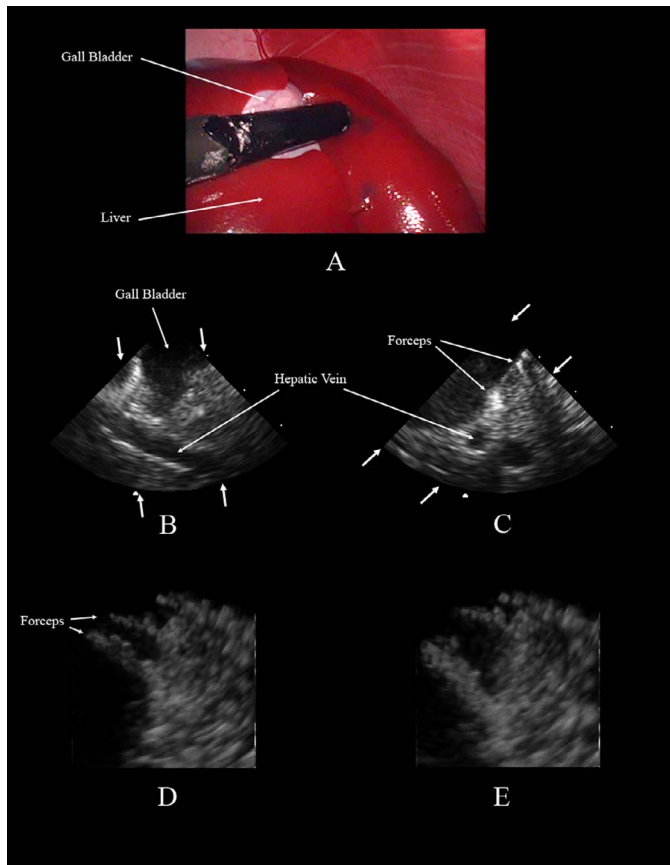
Simultaneous optical laparoscopic view (A) and 3-D laparoscopic ultrasound of the liver and gall bladder. The azimuth (B) and elevation (C) B-scans show the hypoechoic gall bladder and hepatic vein. A pair of surgical forceps [Fig. 2(B)] located between the two organs is visible in the volume-rendered view in both a closed (D) and opened position (E).
